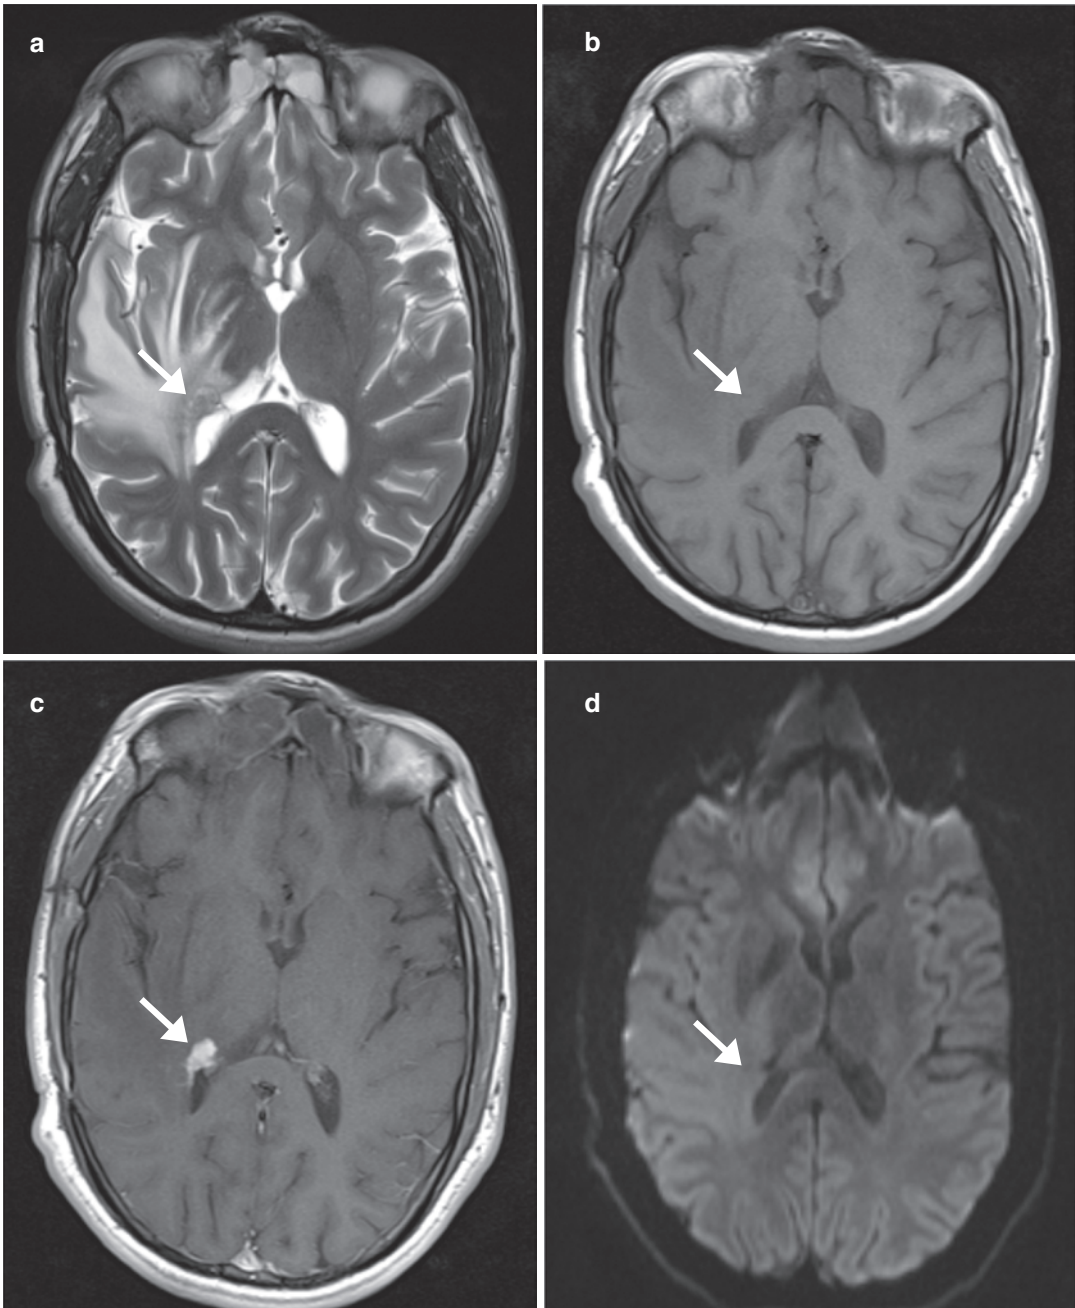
Cerebral parenchymal noncaseating tuberculoma. Axial (a) T2-W, (b) T1-W, (c) contrast-enhanced T1-W, and (d) diffusion-weighted MR images show a right periventricular nodule (arrows) that is T1-isointense
